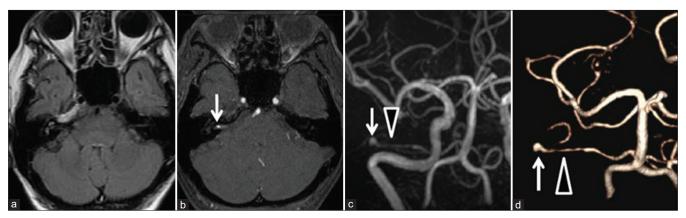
Magnetic resonance imaging at the initial presentation. (a) A fluid-attenuated inversion recovery image of cerebellopontine angle showed no subarachnoid hemorrhage nor mass lesion. (b) A source image of magnetic resonance angiography (MRA) showed a dot (arrow) of arterial flow in fundus of the right internal auditory canal (IAC). (c) MRA showed thinning of right anterior inferior cerebellar artery (AICA) (arrowhead) in premeatal portion of lateral pontine segment and aneurysmal dilatation (arrow) in its meatal portion. (d) Volume rendering image also showed "string (arrowhead) and pearl (arrow)" in the AICA.
